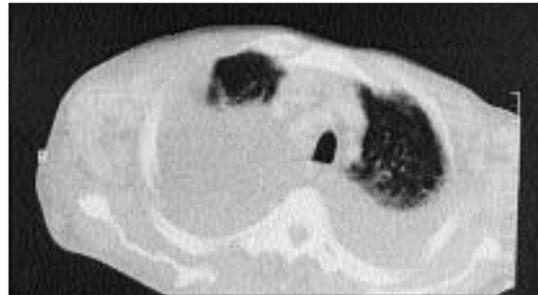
Bilateral pleural effusion, consolidation, multiple mediastinal and axillary lymphadenopathies on CT scan.
